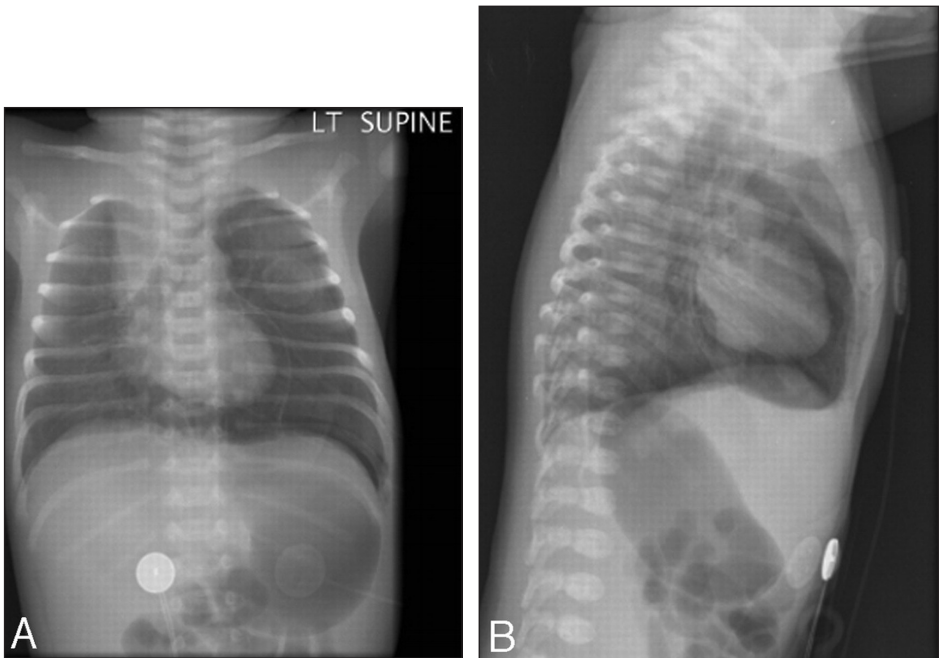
Anteroposterior chest radiograph and lateral chest view.
